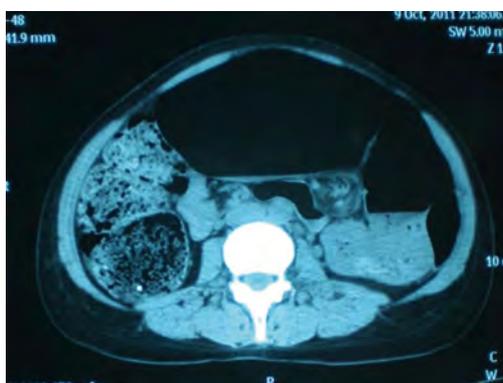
Computed tomography reveals dilated colon with an air/fluid level, as well as the "whirl sign" composed of mesentery and twisted colon.
